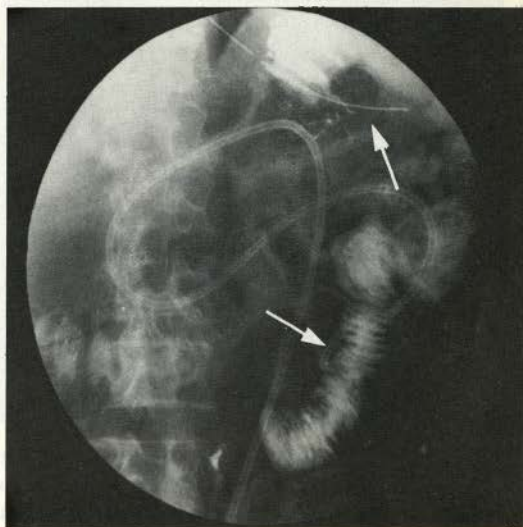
Radiograph showing the catheter in place. The catheter passes into the stomach opposite the upper arrow and thence around the duodenal loop to the jejunum (lower arrow). Some contrast has been injected through the catheter and outlines the jejunal mucosa. The upper arrow points to a nasogastric tube in the proximal stomach which contains some fundal contrast medium.
